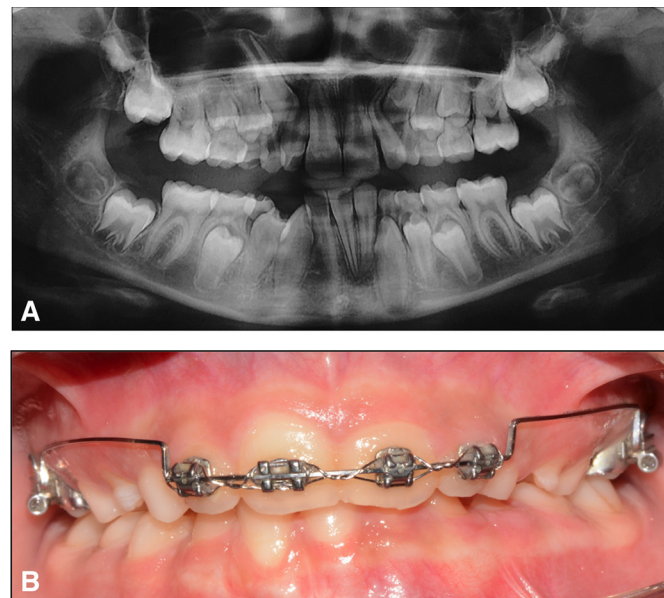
(A) Panoramic X-ray 24 month after the surgery. (B) Intraoral clinical photograph.
